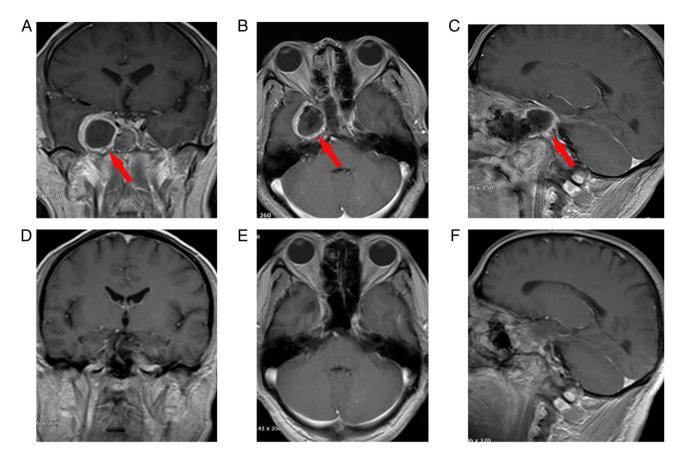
Post-operative imaging. A and D coronal sections, B and E transverse sections and C and F sagittal sections. (A-C) MRI scans taken 1 week after the operation, which indicated that the TS was totally resected without destruction of the sphenoid sinus and intracranial hemorrhage. The posterior wall of the maxillary sinus was removed and the residual cavity of the tumor was covered with a circle of T2 high signal intensity (red arrows indicate the T2 high signal intensity). (D-F) MRI scans taken 3 months after operation, which indicated that the TS residual cavity and the T2 high signal circle had disappeared. The anatomical structure of the brain returned to normal. MRI, magnetic resonance imaging; TS, trigeminal schwannoma.
